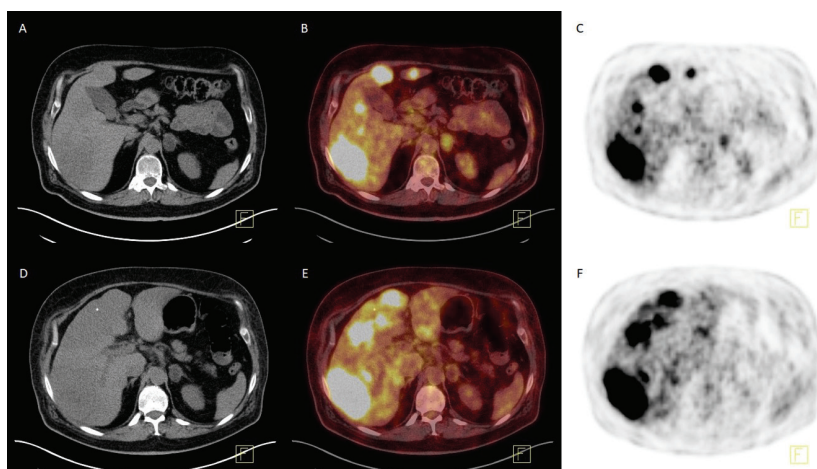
¹⁸F-FDG PET/CT scan was performed on a 51-year-old patient who was diagnosed with anaplastic thyroid cancer from a nodule found in the left lobe of the thyroid gland. On the axial PET, CT, and fused PET/CT images obtained (A, B, C), a nodular lesion with increased ¹⁸F-FDG uptake was observed in the left adrenal gland, except for lung, liver, and bone metastases (SUV_{max}: 5.8 g/mL). Although progression was detected in metastatic foci in ¹⁸F-FDG PET/CT images (D, E, F) taken after chemotherapy (carboplatin and paclitaxel) regimen, it was noted that the metabolic activity of the morphologically stable left adrenal nodular lesion regressed (SUV_{max}: 3.7 g/mL). On magnetic resonance imaging, the lesion was reported to be compatible with adrenal adenoma. Increased ¹⁸F-FDG uptake is observed in only 5% of adrenal adenomas, which is common in oncologic imaging practice (1). In the literature, the effectiveness of semi-quantitative ¹⁸F-FDG PET/CT parameters, primarily SUV_{max}, in differentiating adrenal lesions as benign or malignant at different threshold values has been evaluated with various reports (2,3,4,5). Although there are several descriptions regarding the alterations in ¹⁸F-FDG uptake patterns observed in adrenal adenomas, especially possible circadian rhythm of the hormone-secreting tissues, as well as the differences in the cell content of the lesions (especially cell content with increased GLUT1 expression), information on this issue is still limited (6,7,8). Considering the variability of ¹⁸F-FDG uptake of adrenal adenomas as we presented in our cases and possible differences in clinical-technical characteristics between scans (serum glucose level, fasting period, injection time, and time between imaging and injection), we wanted to highlight the limitations in cross-sectional evaluation of adrenal lesions with a single PET/CT imaging.
